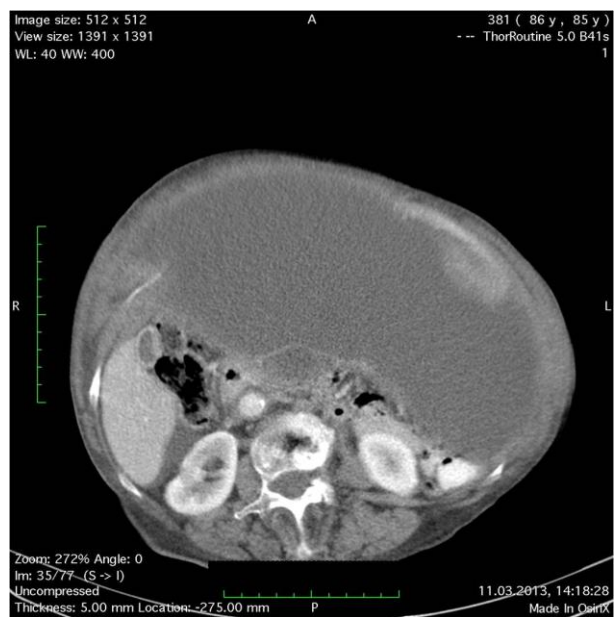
CT aspect - Abdominal level: large mass with axial diameter of 29/15 cm and a cranial-caudal diameter of 25 cm, originating in her left ovary
